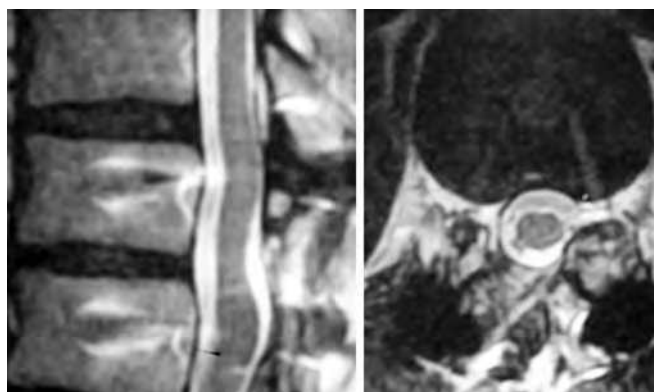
Postoperative magnetic resonance imaging in a representative case.
